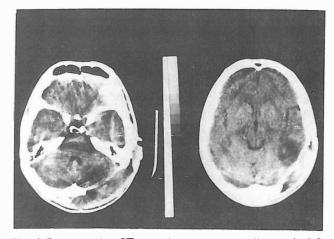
Postoperative CT scan shows porencephalic area in left cerebellar hemisphere.
